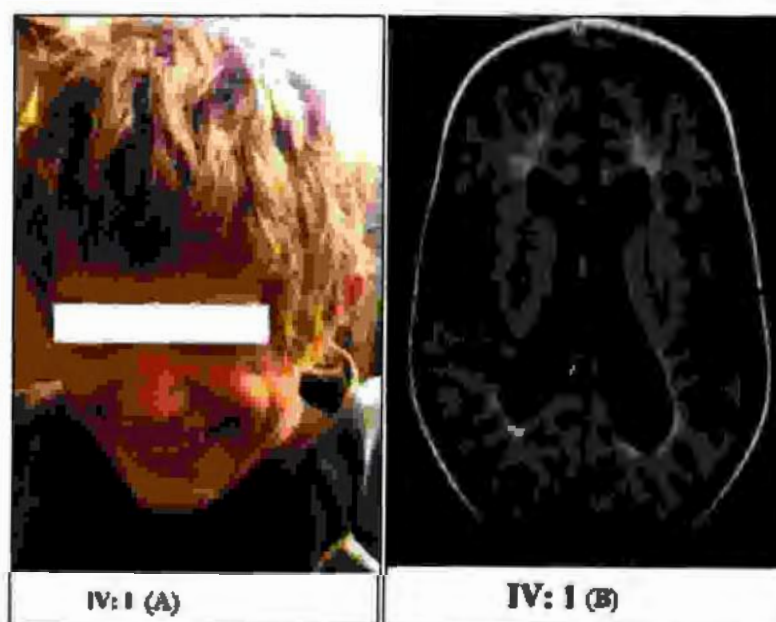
(A). The proband (IV: 1) phenotypes demonstrated dysmorphic facial feature with broad nose, (B). Brain CT Scan revealed progressive a trophy, cerebral white matter in the cerebellar hemispheres in patients
